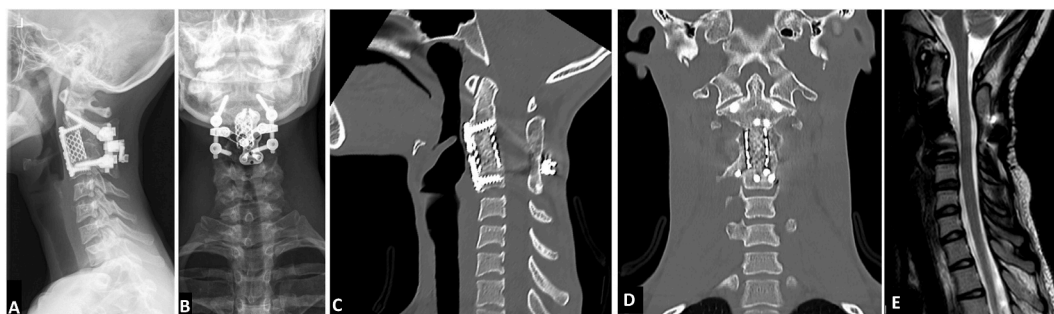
Follow Up at 10years: (A) Lateral radiograph, (B) AP radiograph, (C) CT sagittal reconstruction, (D) CT coronal reconstruction, (E) MRI sagittal image.
